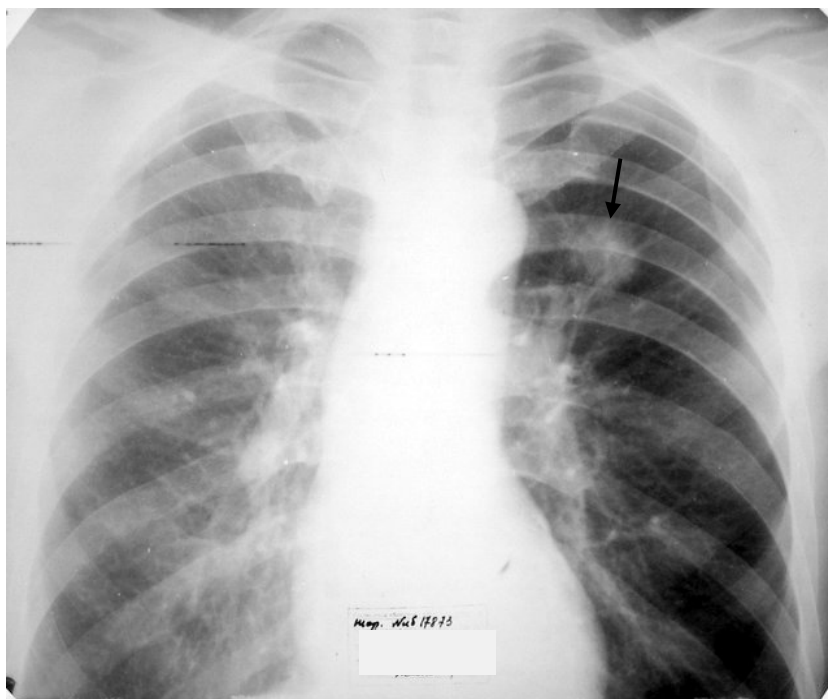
The frontal chest radiograph.
